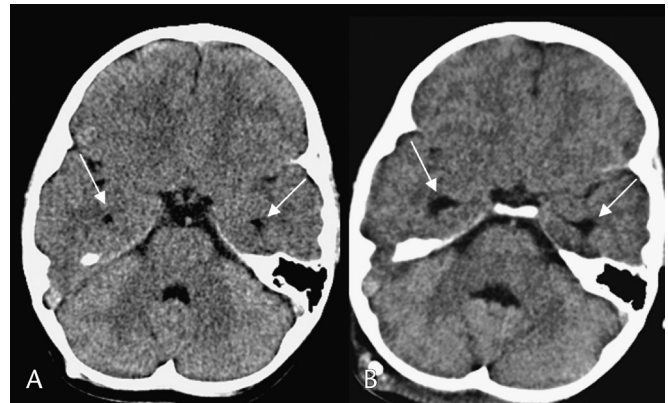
Shunt malfunction. Noncontrast CT (A) at baseline. Noncontrast CT (B) at presentation for shunt malfunction, in comparison with the previous baseline CT, shows only a slight increase in size of the temporal horns (arrows).
